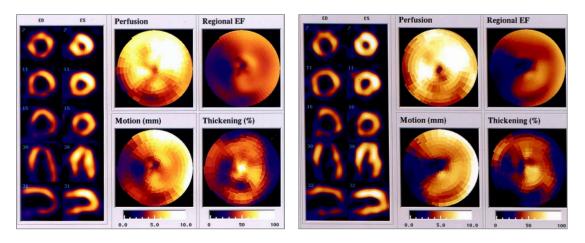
M*, 57 y, retrosternal pain, DM (7 y of treatment for DM). SPECT-gated in stress and rest - partial reversible defect in inferior wall of LV; hypoperfusion partially reversible in antero-septal wall; we have noted good perfusion of the septum but with hypomotility and absence of systolic thickening (stunned myocardium?);
